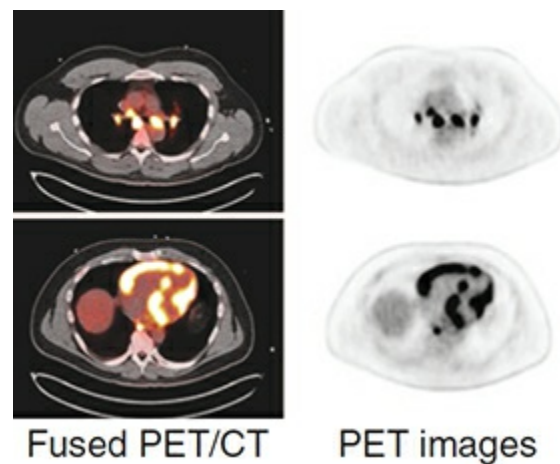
Axial PET-only and PET/computed tomography (CT) images of the mediastinum (upper row) and the left ventricle (lower row). Multiple foci of intensely increased ^{18}F -FDG uptake are seen in the mediastinum (consistent with mediastinal lymph node involvement) and throughout the left and right ventricular myocardium.
